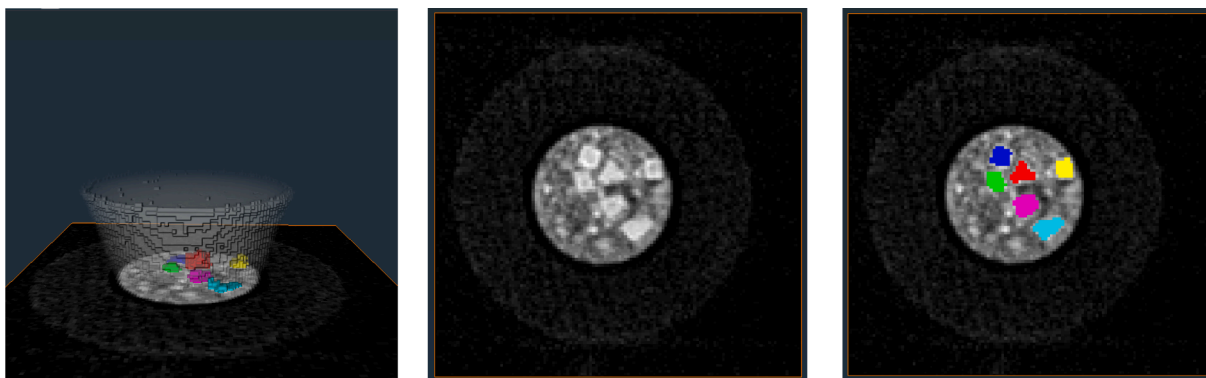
Examples of 3D views reconstructed from 3D UTE MRI images of the large cheese particles.
